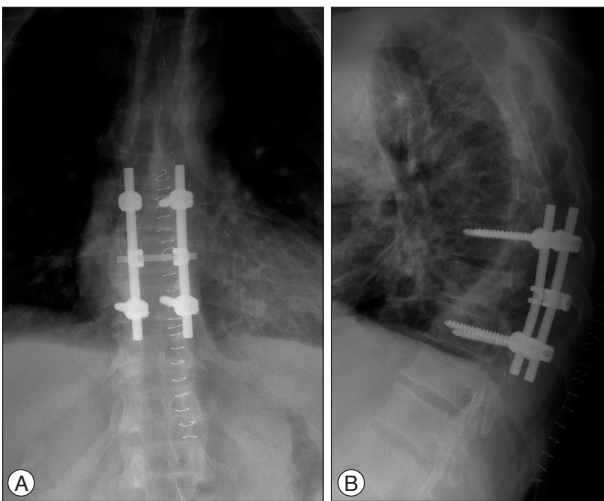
AP (A) and lateral (B) X-Ray images demonstrate a short segment spinal instrumentation and fusion with transpedicular screws and rods at the level of T8–10.
